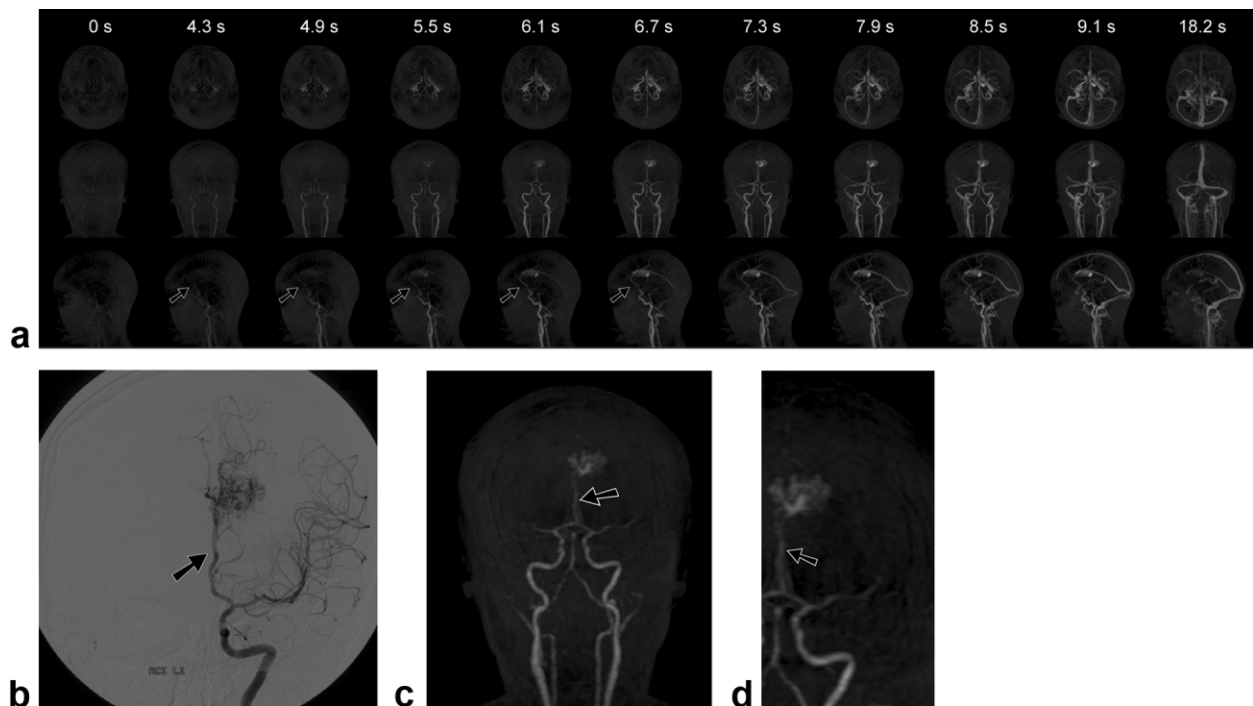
Depiction of the arterial feeder (pericallosal artery, arrow) of a left parasagittal cAVM (nidus size: 2.7 cm) in a 23-year-old female as visualized in 11 of 50 dynamic phases (maximum intensity projections; transverse, upper row; coronal, middle row; sagittal, lower row) of the 3D T1-weighted gradient echo sequence provided by 4D-TRAK (a, magnified: c,d), and in the arterial phase of DSA (a.p. view) after selective catheterization of the left common carotid artery (b), confirming the arterial feeder from the anterior cerebral artery (arrow).
